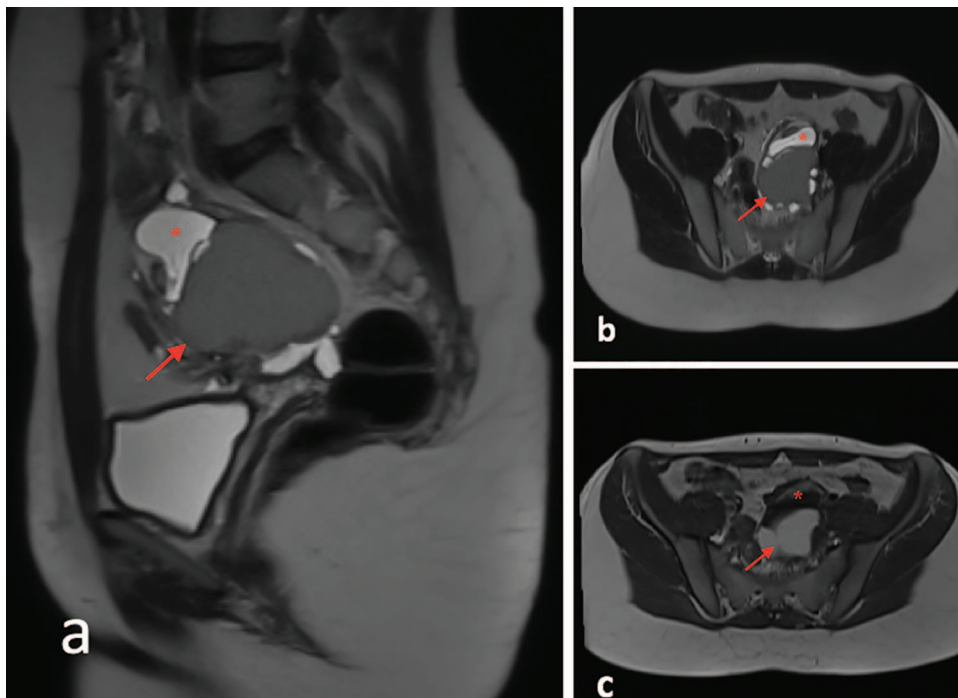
MR images of Case 1. (A) Sagittal and (B) axial T2-weighted, and axial (C) T1-weighted MR images show an endometrioma (arrow) and a dermoid cyst (*) within the same ovary.
